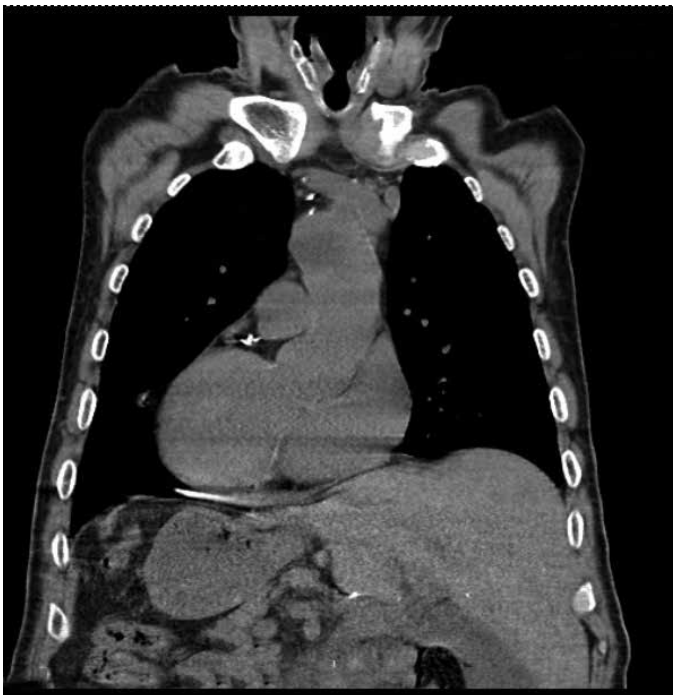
Computed tomography of thorax
